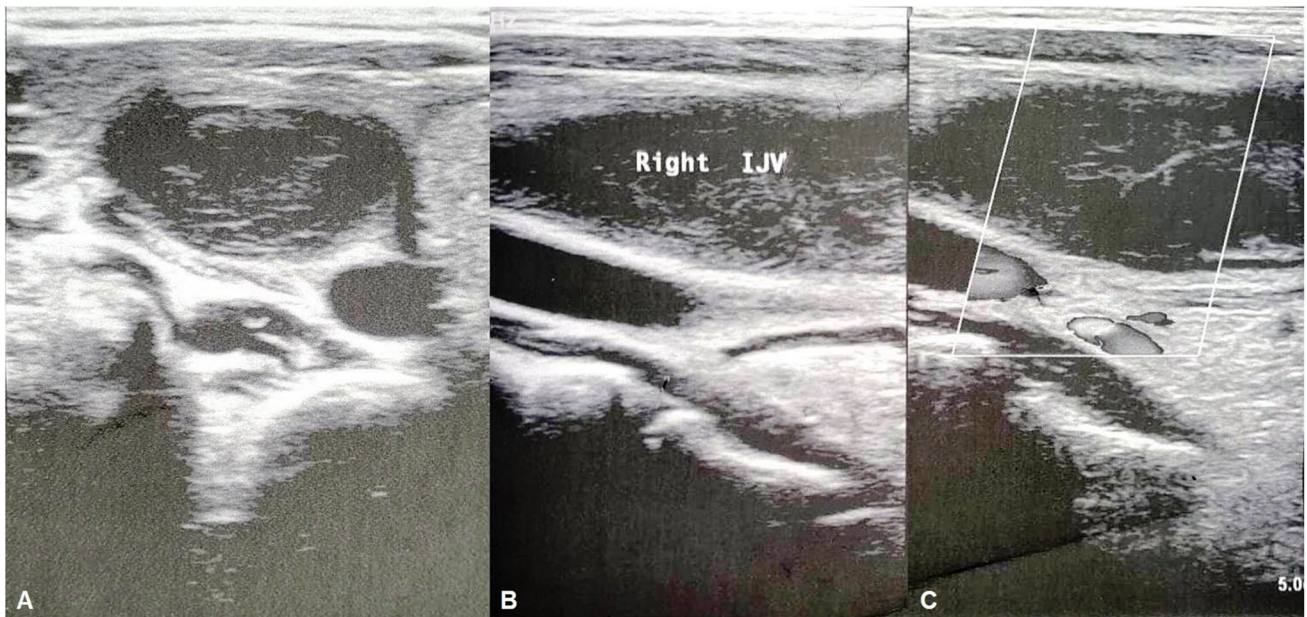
Axial (A) and longitudinal (B and C) gray images showing distended right internal jugular vein with echogenic content within. Color Doppler images show no flow within.
